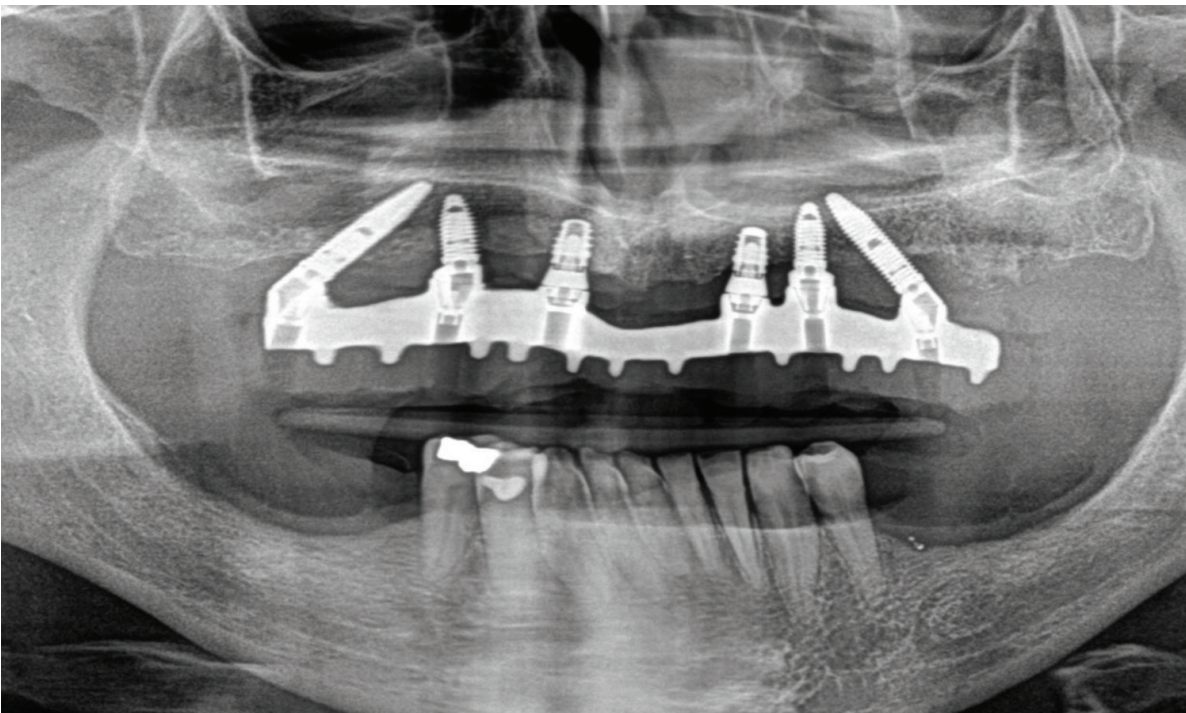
Postoperative radiography at one year.
